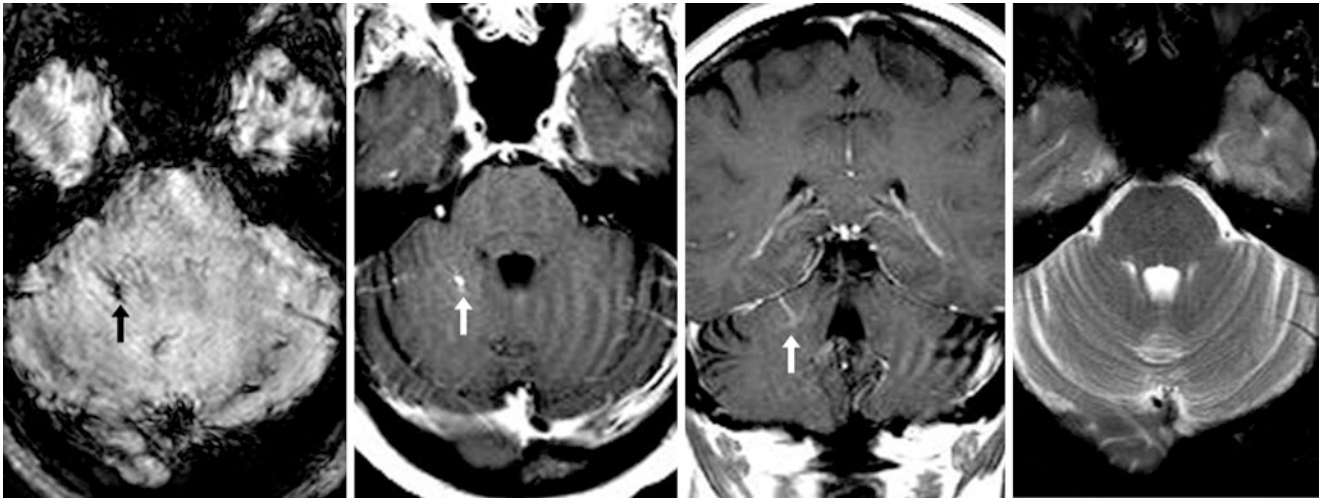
A 49 year old with headaches and syncope underwent an otherwise negative 1.5T brain MRI that depicted a small draining vein (arrows) arising from a tuft of enhancement within the superior right
